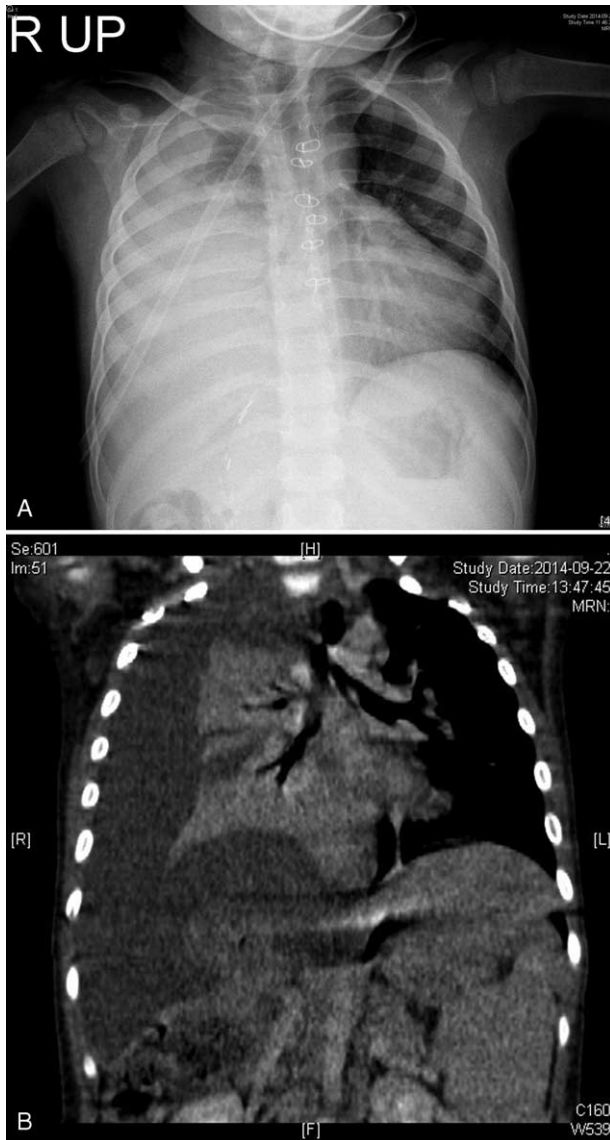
(A) Chest X-ray and (B) computed tomography of the patient (Case 3). There is massive pleural effusion in the right thorax.
